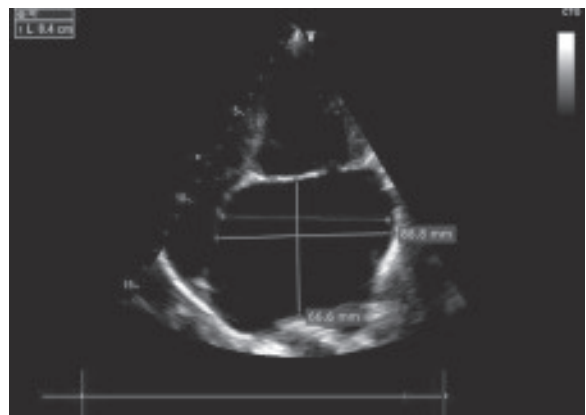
Apical 4-C view showing dilated LA (66 mm X 88 mm)
